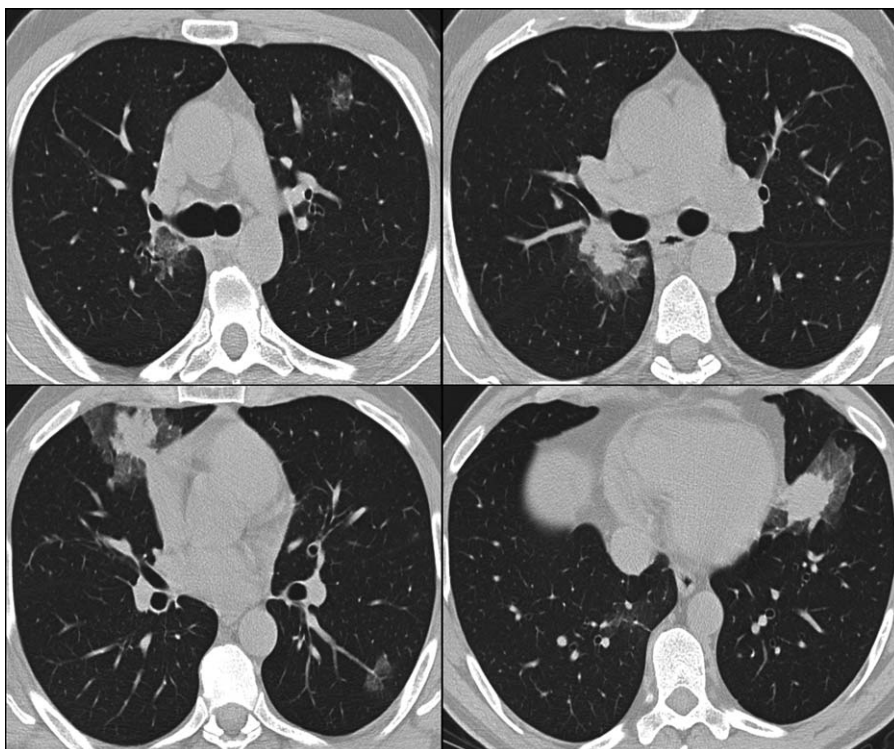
Patient 3. CT scan shows several consolidations with halo sign, the biggest in the right middle lobe. Some ground glass lesions are also present; the biggest in size is in the posterior segment of right upper lobe.
